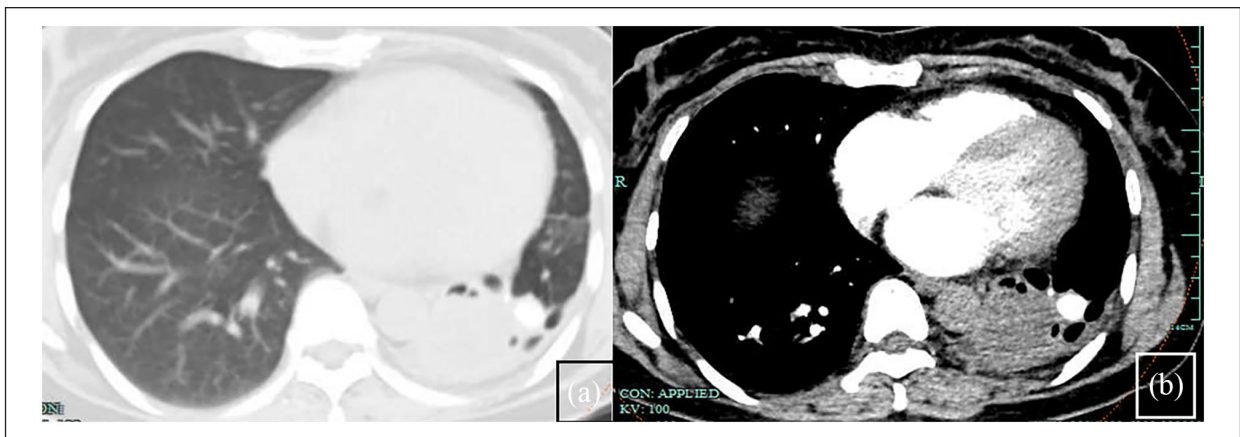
Chest computed tomography images acquired after admission, demonstrating atelectasis of the left lower lung, with consolidation, without enhancement after augmentation, shown in lung window (a) and Mediastinal window (b), respectively.
